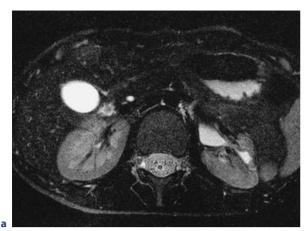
Renal scarring in a 5-year-old girl with recurrent UTI. a High-resolution axial T2-weighted images showing transmantle scarring of the left kidney with associated dilatation of the adjacent calyx. b Delayed coronal MIP from the dynamic series demonstrates a generally small left kidney with multiple cortical scars associated with clubbed calyces
